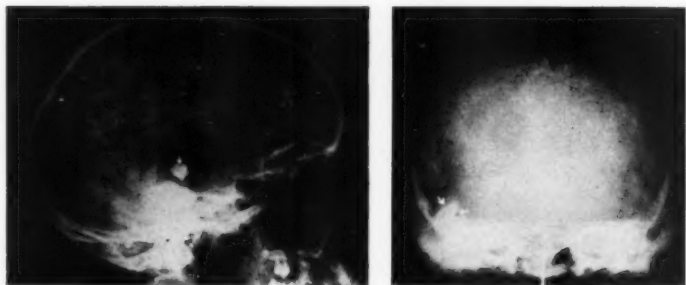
(b). Lateral and anterior radiographs showing the contracted cicatrix five months after completion of treatment, in the same case. For two months after discharge the patient had been irritable, aggressive, and emotionally labile. At the time these films were taken his mental state was normal, and the only residual disability was a left homonymous hemianopia. There were no further seizures.
